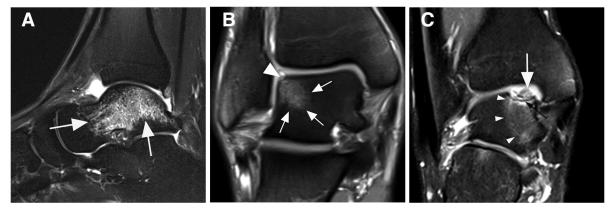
Bone injury on proton density—weighted magnetic resonance imaging. (A) A large talar bone contusion (grade 2) involving the talar body and talar neck is shown (arrows). No fracture line is seen. (B) Acute osteochondral injury to the lateral talar shoulder (grade 4). In addition to the bone contusion (arrows), a discrete acute surface lesion of the articular cartilage is shown (arrowhead).(C) Chronic osteochondral lesion of the talus (grade 5). An osteochondral fragment (white arrow) is unstable with a corresponding demarcated sclerotic rim at the talar dome (black arrow). There is also a large associated bone marrow lesion in the talar body (arrowheads).
